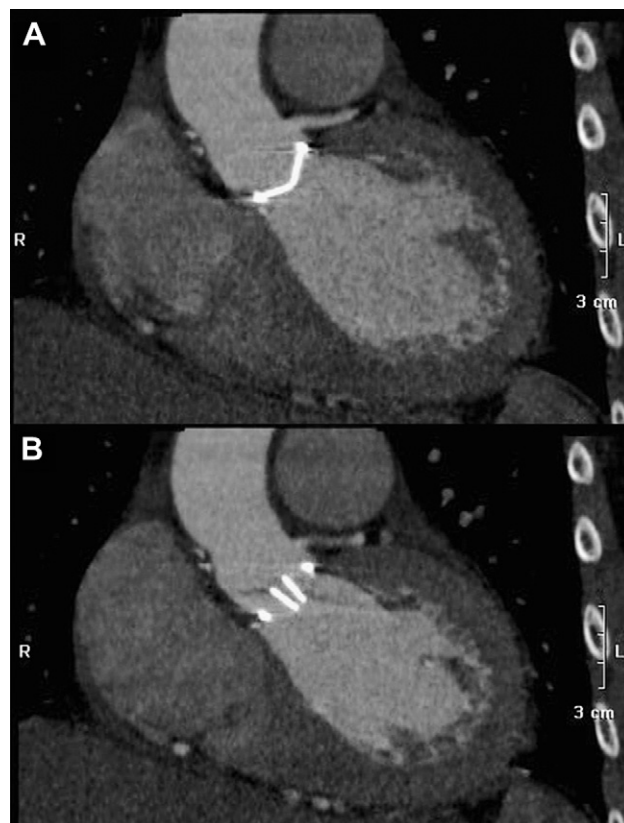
Multidetector computed tomography coronal angiography shows a normally functioning mechanical St. Jude bileaflet aortic valve (St. Jude Medical, St. Paul, MN, USA) in diastole (A) and systole (B). Minimal artifact allows for accurate opening and closing angle measurements.
